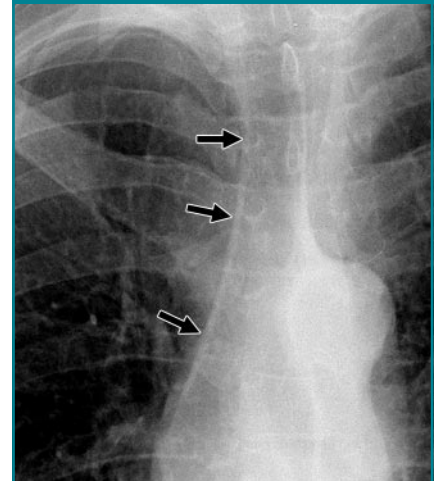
Magnified chest radiograph shows paratracheal stripe (arrows).
